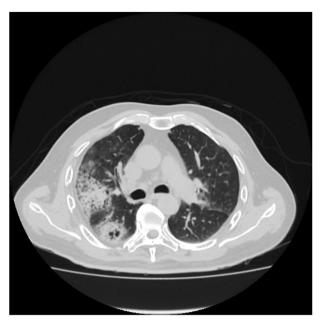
HRCT-Thorax showing consolidation in right upper lobe and a cavity in the apical segment right lower lobe.
